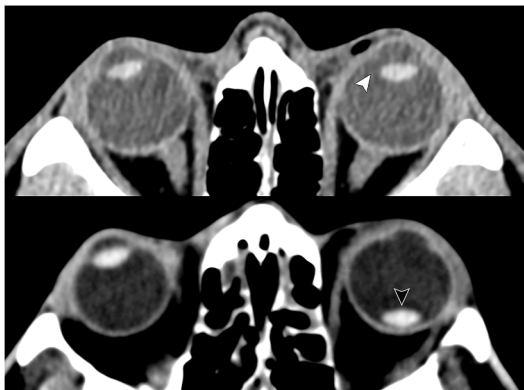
Axial CT orbits demonstrating a left lens subluxation (white arrowhead) and posterior dislocation (black arrowhead).
